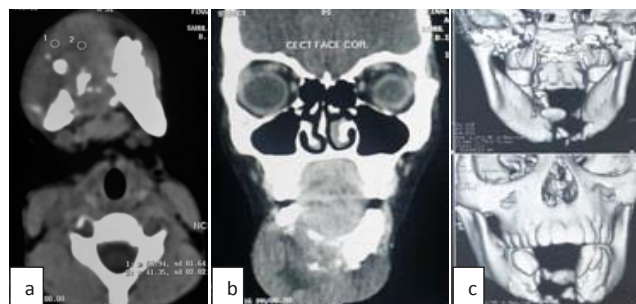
a,b,c) CT Scan axial and Coronal view with 3D reconstruction showing extent of the mass and erosion of central part of mandible.
